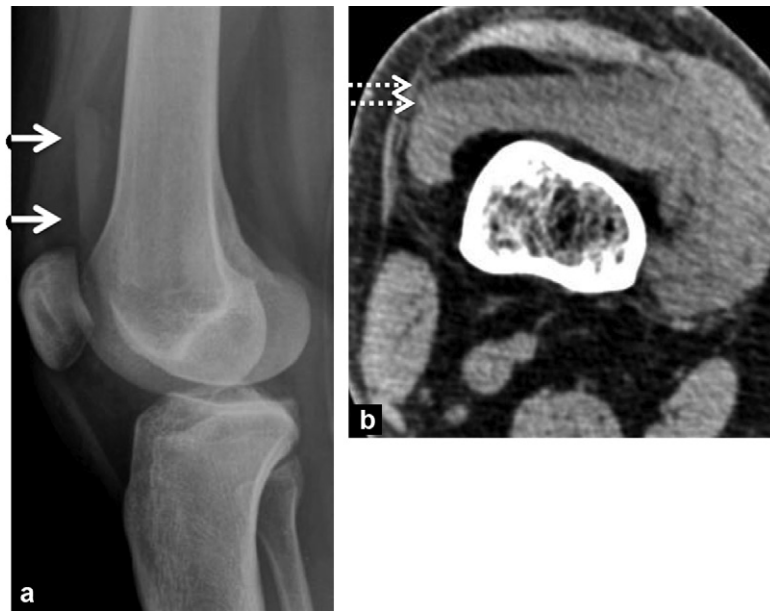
Lipohemarthrosis. a: lateral radiograph demonstrates a fat-fluid level in the effusion, attesting to a supernatant fat level (full arrows); b: CT (axial reformat) shows two levels, defining three strata, surface fat, hematic sediment in depth (dotted arrows).
